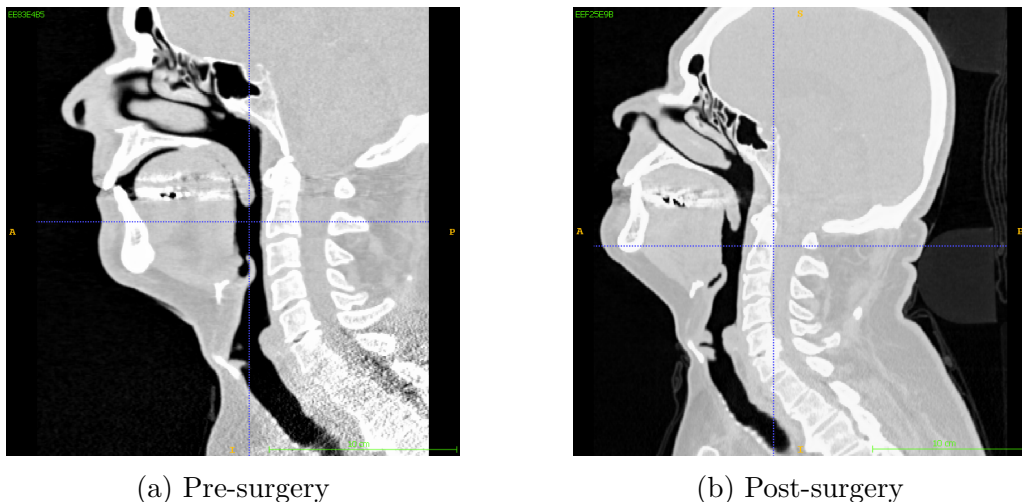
(a) and (b) show the different head position of patient number 12 in the pre- and post-surgical CT recordings, respectively.
